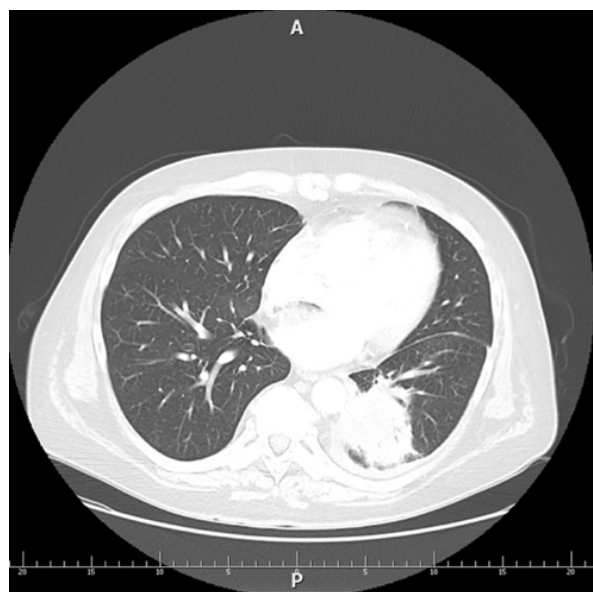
Computed tomography with contrast. In segments IX and X of the left lung, an irregular infiltrative lesion measuring $8 \times 7 \times 6.3$ cm is visible
